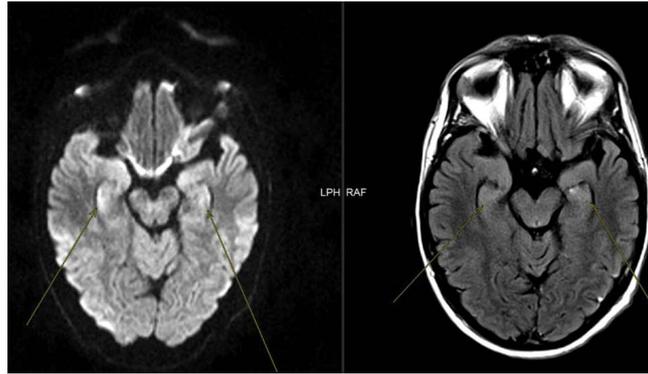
MRI brain showing hyper-intensities on T2-weighted FLAIR images involving the bilateral hippocampi with mild restricted diffusion suggestive of limbic encephalitis (marked by arrows).
